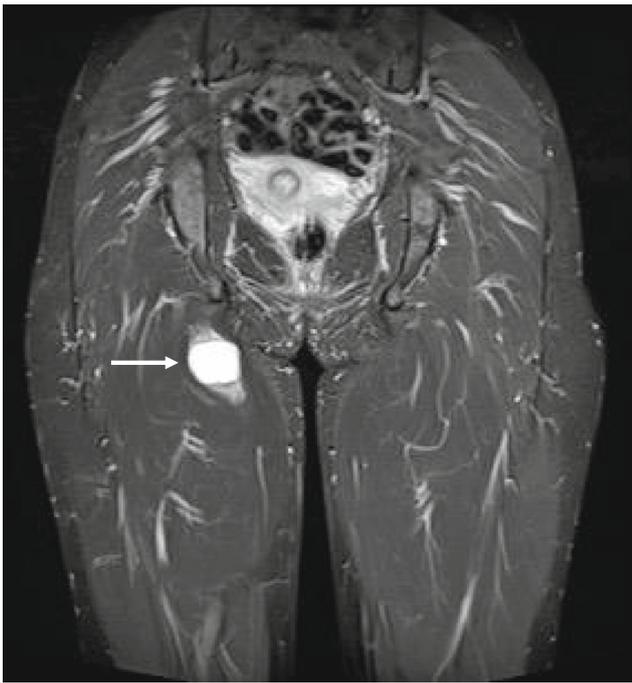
Coronal short tau inversion recovery (STIR) MR image through the pelvis shows a hyperintense rounded mass lying in the posterior aspect of the adductor magnus (*arrow*). Oedema-like signal can be seen at the superior and inferior aspects of the mass
